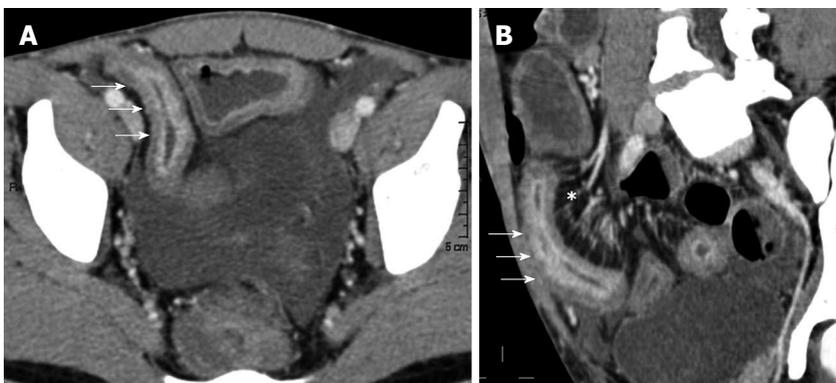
Transverse (A) and MRP sagittal (B) computed tomography show stratified enhancement of terminal ileum (arrows), and hyperemic mesentery with the "comb sign" (asterisk).
